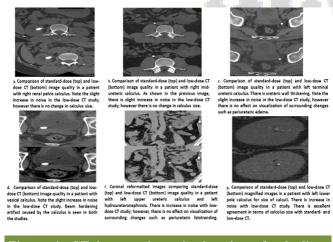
CT images show the location of calculi at various sites
